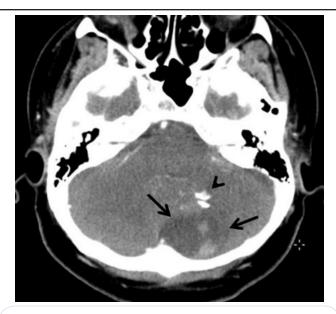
The computed tomography showed a heterogeneous cystic mass (arrows) in the left cerebellum with a calcified solid nodule (head arrow).
